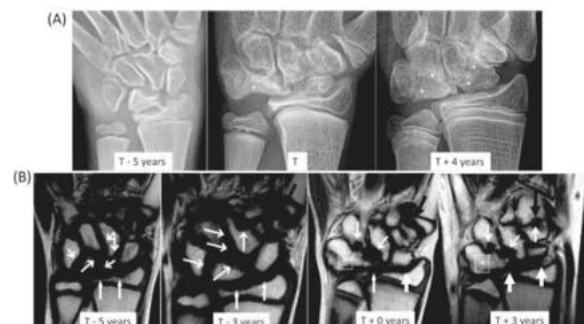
Images of the left wrist. (A). The left wrist's frontal radiographs show numerous erosions in the carpus, proximal metacarpals, and distal radius along with progressive carpal fusion (*) and loss of joint space. Multiple growth recovery lines and overgrown distal radius and ulna epiphyses are visible posttreatment.
